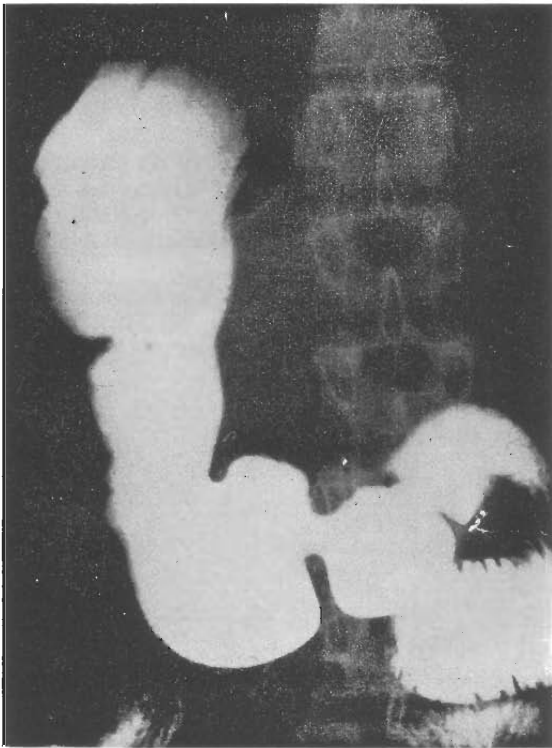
X-ray of the stomach showing its dextroposition.
